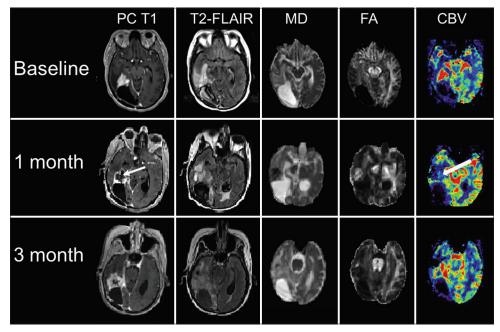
Axial coregistered postcontrast T1-weighted image (PC T1), T2-FLAIR, and corresponding mean diffusivity (MD), fractional anisotropy (FA), and cerebral blood volume (CBV) maps are shown at baseline, 1-month, and at 3-month follow-up periods. There was a striking reduction of contrast enhancement, and CBV (white arrows), more apparent at 1-month follow-up compared to the baseline, with increased MD and decreased FA.
